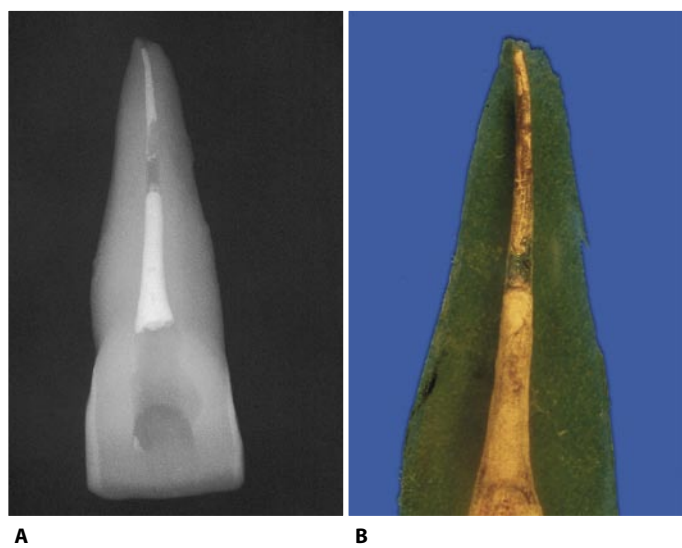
A. Too rapid withdrawal of the needle from the root canal leaves empty spaces within. B. The same tooth after it has been made transparent. The empty space seems smaller than in the radiograph because of the small streak that partly conceals it.
